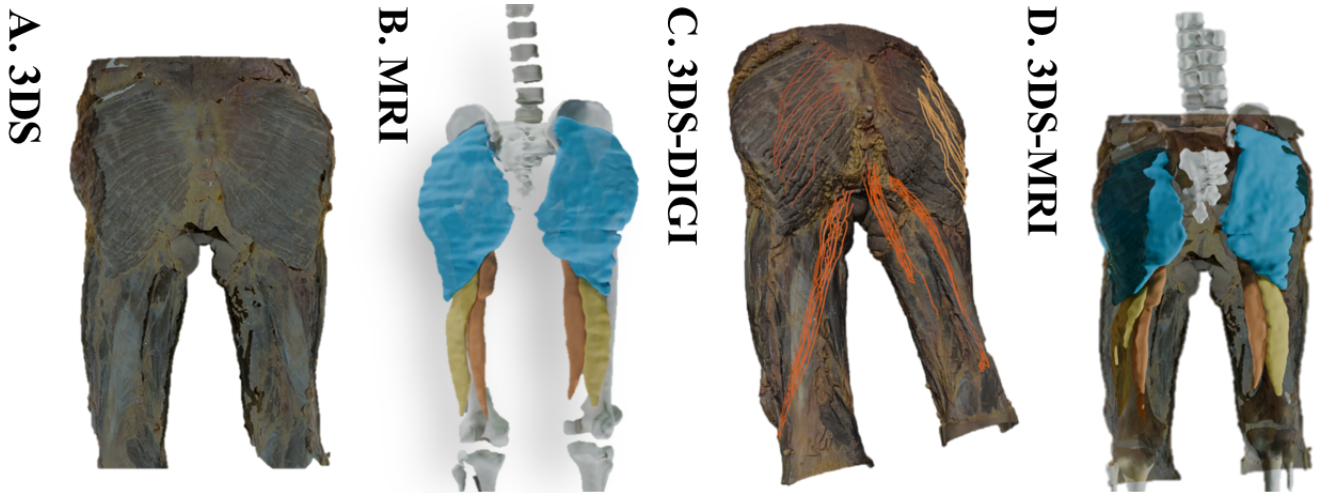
A) 3DS in prone position, dissection layer 1. B) The MRI 3D model of the muscles and bones in prone position, dissection layer 1. Muscles, GMax (blue), ST (orange) and BFlh (yellow). C) Co-registered 3DS-DIGI, showing muscle fibers in prone position, dissection layer 1. D) Co-registered 3DS-MRI, showing the data of image A and B combined. In B & D the thigh and leg bones are also modeled and aligned to give anatomical perspective.
